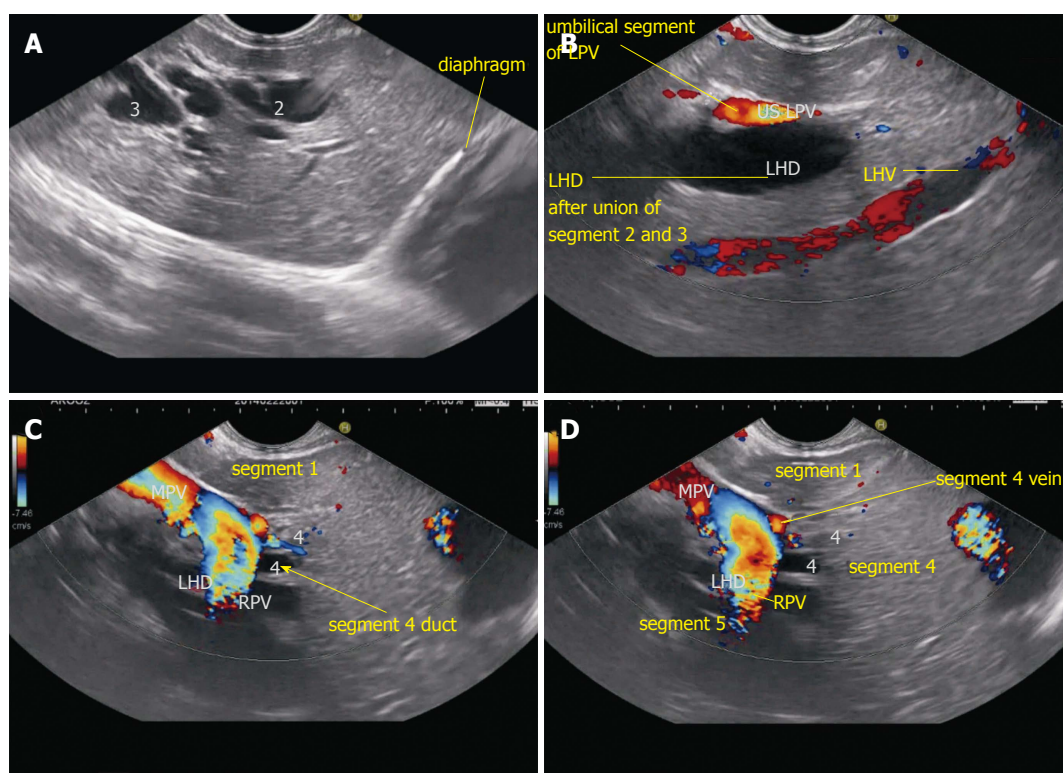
Segmental ducts as seen on endoscopic ultrasound. A: The dilated ducts of segment 2 and 3 ducts are seen in an open position to left; B: On clockwise rotation the segment 2 and 3 ducts fuse together in front of umbilical part of left portal vein. The left hepatic vein is also identified going from 2 o'clock position to 7 o'clock position; C: On further clockwise rotation the fused part of segment 2 and 3 ducts is joined by segment 4 duct from the cranial aspect (arrow) in front of the transverse segment of left portal vein; D: On further clockwise rotation the right portal vein is seen joining the left portal vein and the liver segment lying below the plane of right portal vein belongs to segment 5. RPV: Right portal vein; LPV: Left portal vein; LHD: Left hepatic duct; LHV: Left hepatic vein.
